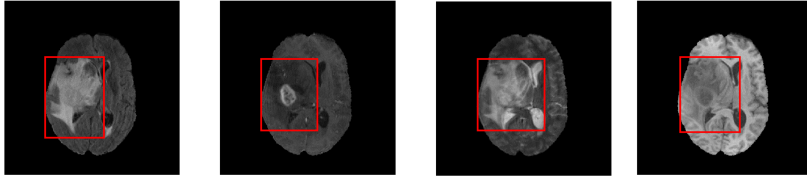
Four images from T1, T2, T1CE, and Flair MRI modalities with brain tumors having different shapes, sizes, and textures (Brain tumor is highlighted in red boxes).
